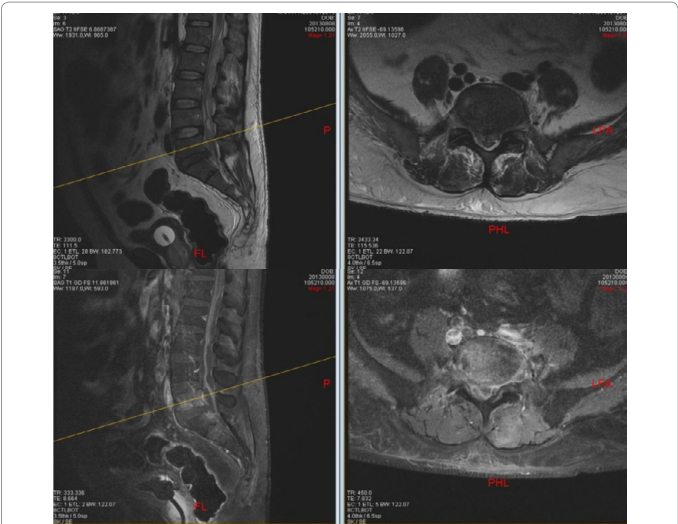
Simple and contrast enhanced MRI in sagittal and axial views. T1 hypointense, T2 hyperintense and contrast enhanced soft tissue lesion involving L5-S1 vertebral disc, L5 and S1 vertebrae and paravertebral tissue extension with a left psoas abscess. CT-guided biopsy reported chronic and acute osteomyelitis.
